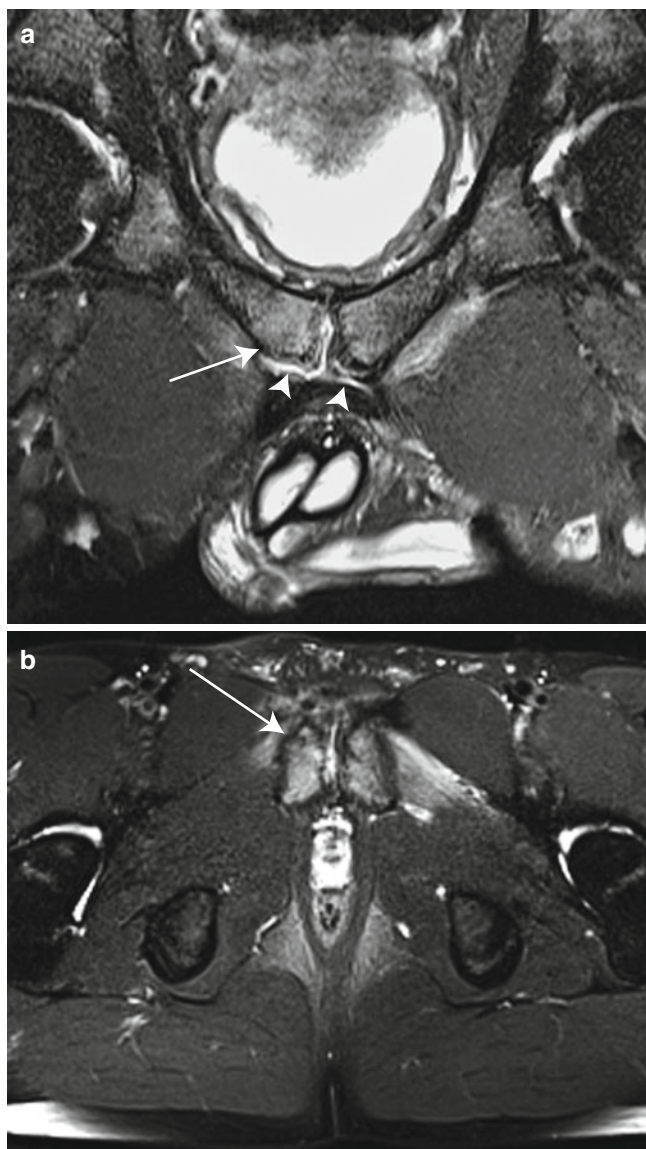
Coronal oblique (a) and axial (b) MR images show bright bone marrow edema (arrows) on both sides of the pubic symphysis indicating osteitis pubis. A large detachment of the pubic plate (arrowheads) is also visible on the coronal oblique image
